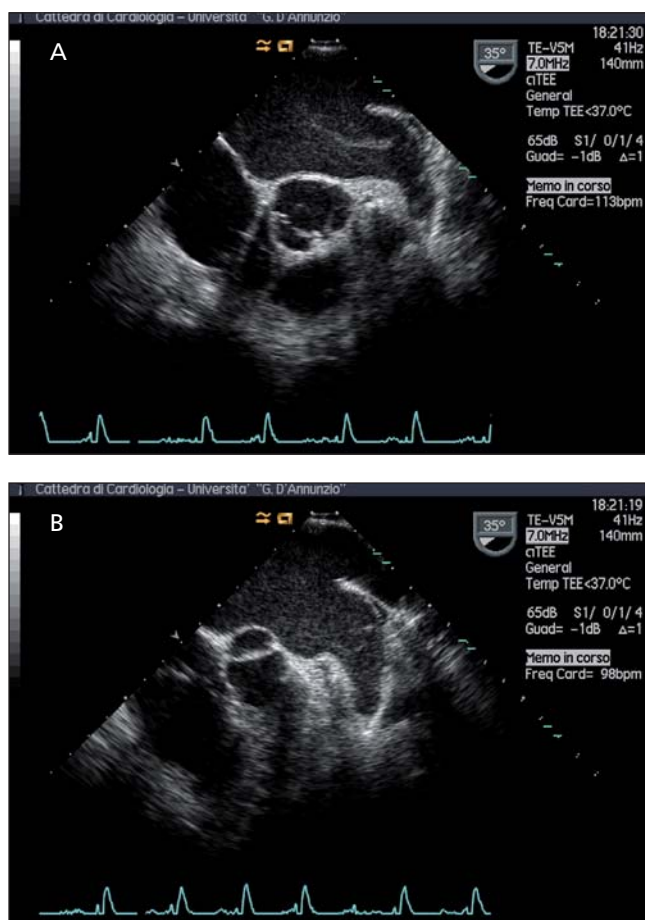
Transoesophageal echocardiography performed after 1 month of therapy with dabigatran etexilate. No thrombotic masses are evident in the atrial appendage and over the left atrial septum, documenting the complete resolution of the previous thrombus.
